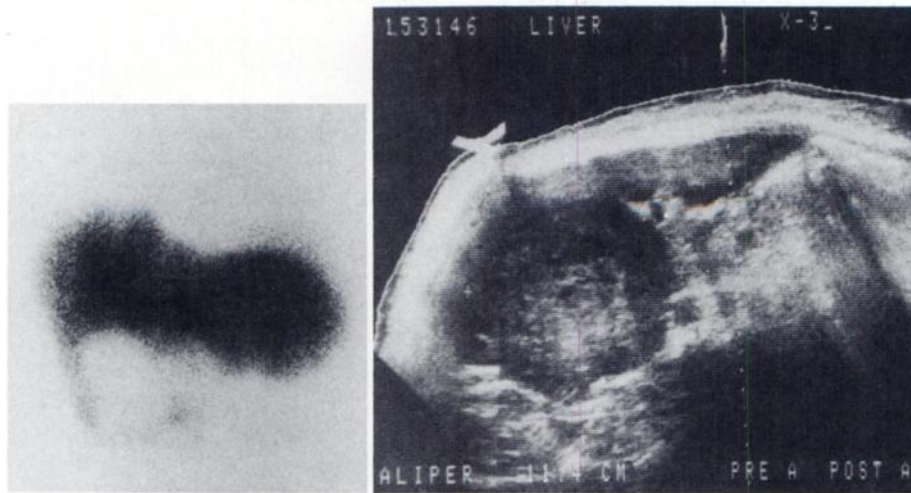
Left: sulfur colloid liver image shows large photon-deficient area in right lobe. Right: ultrasonogram shows large mass with internal echoes.
